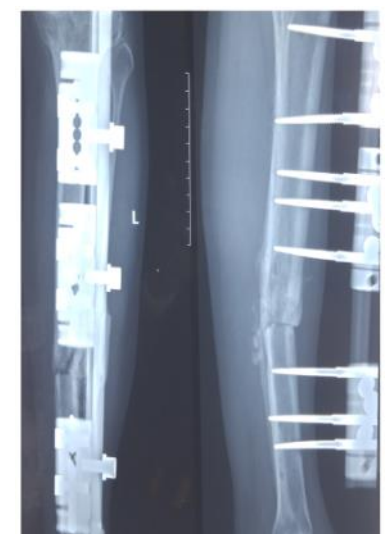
4 Months Follow-up Xray
